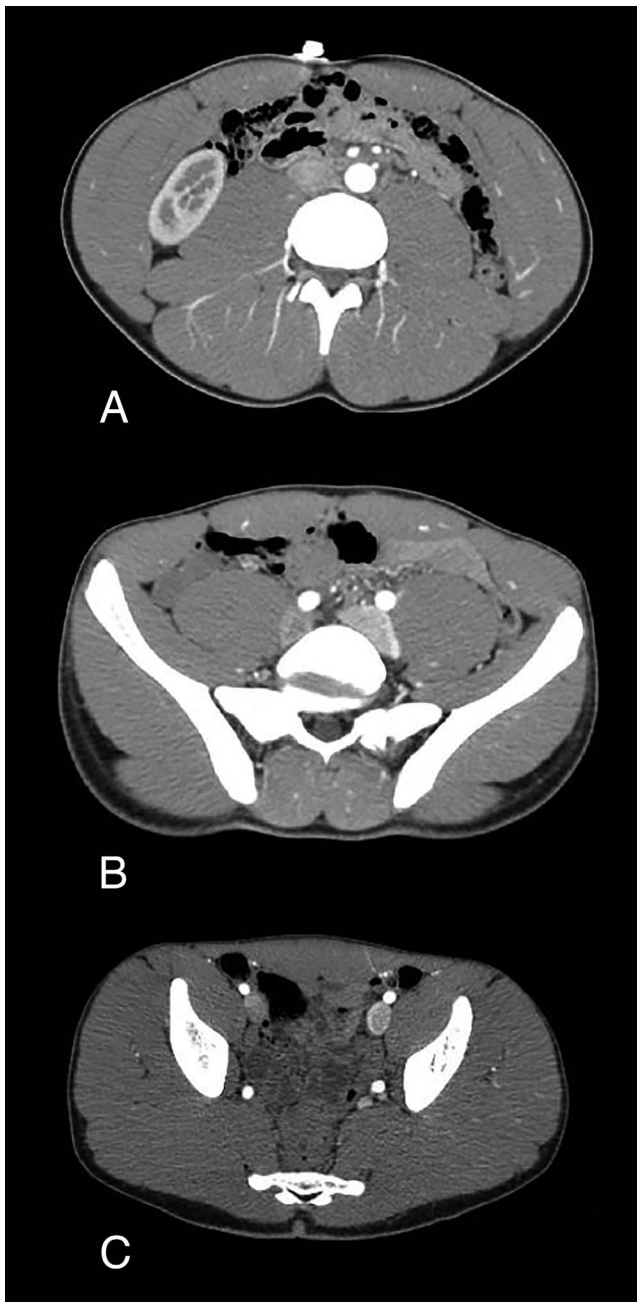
Axial computed tomography angiography images show (A) the level of the takeoff of the inferior mesenteric artery from the aorta; (B) normal bifurcation of the aorta into the common iliac arteries; and (C) the level of the internal and external iliac arteries. The internal iliac arteries are prominent but not aneurysmal.
